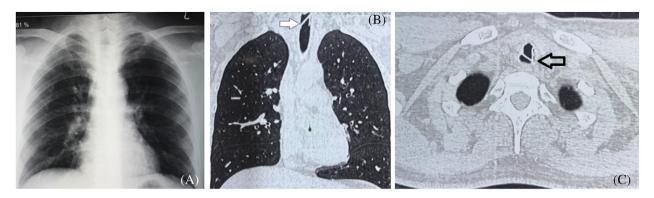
Images on the patient. (A) An apparently normal-looking chest x-ray; (B and C) CT scans showing a suspicious foreign body (arrows) in the trachea.
